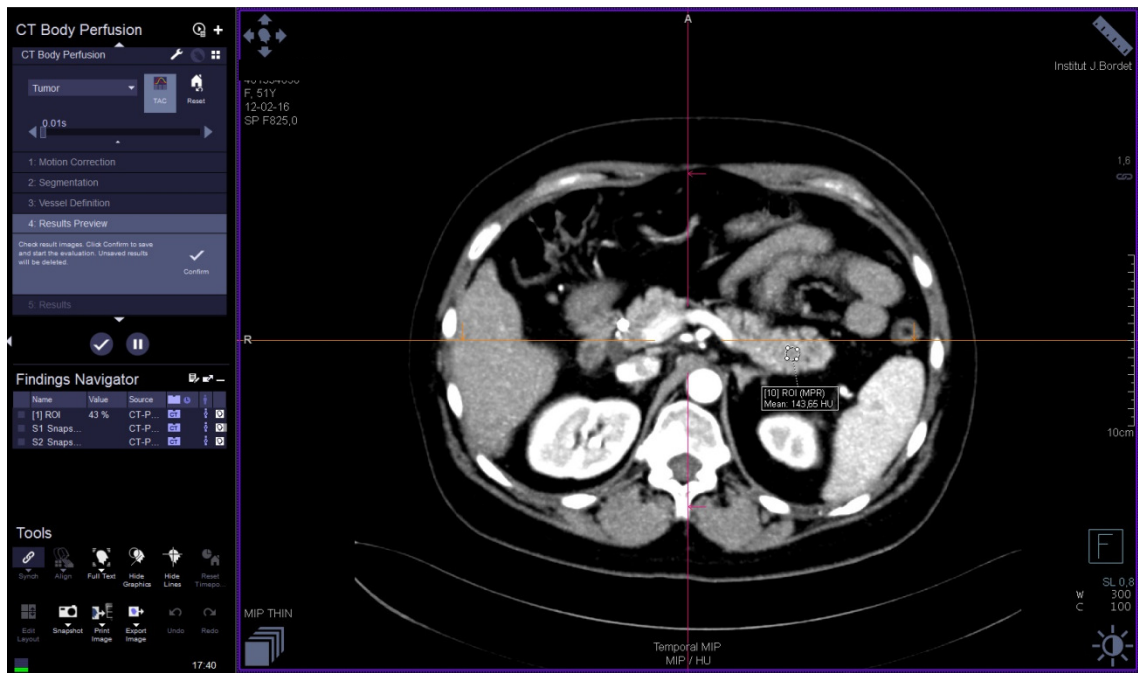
(B). CT ROI positioning in pancreatic tail.
